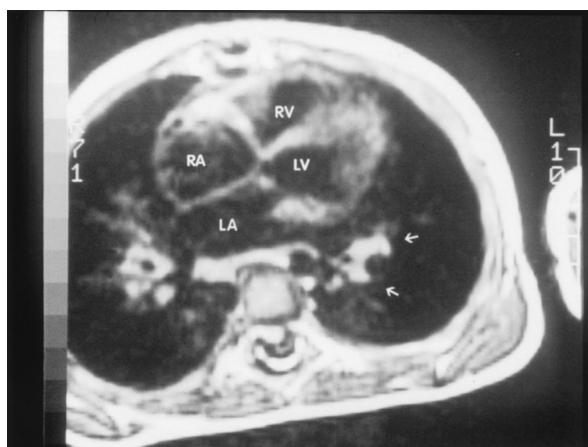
Magnetic resonance imaging showing the intussusception of the left atrial appendage (*arrows*). *LA*, Left atrium; *LV*, left ventricle; *RA*, right atrium; *RV*, right ventricle.
